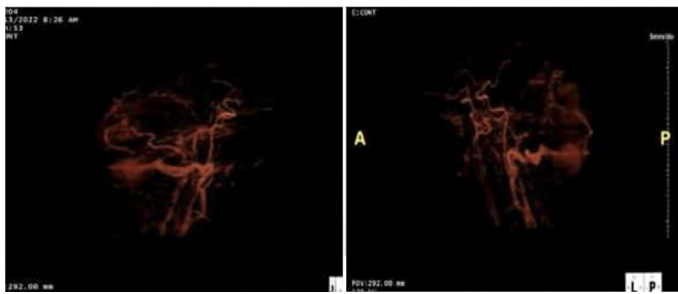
Shows CT angiography with the 3D reconstruction of the right neck AVM.
